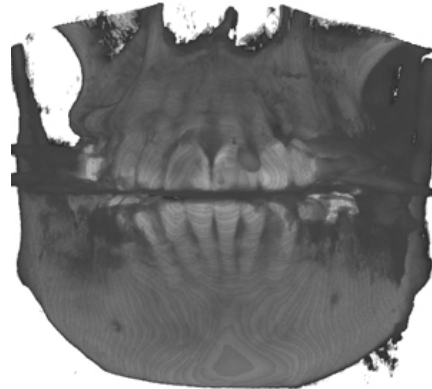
Front view of a raw CBCT volume.
